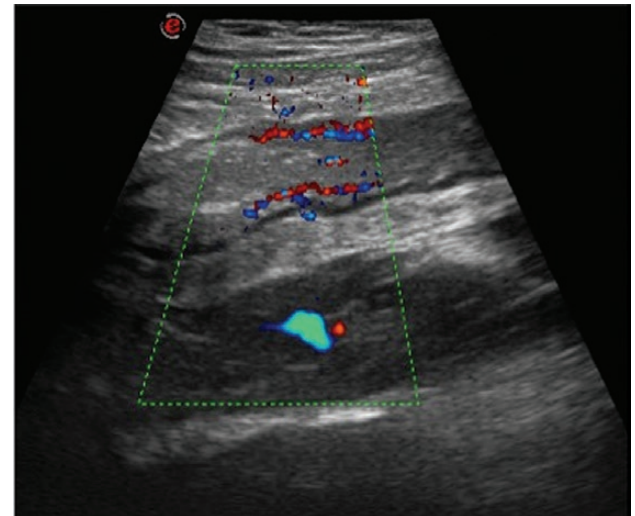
Power-Doppler ultrasound image of the affected CD segment shows moderate mural blood flow.
